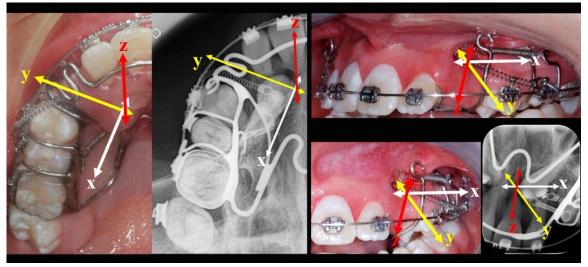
Clinical and radiographic images of palato-buccal movement in the y-axis (yellow arrow), mesio-distal movement in the x-axis (white arrow), and extrusive movement in the z-axis (red arrow) of palatally and buccally MIC with Ni-Ti closed coil springs activated over the rigid anchorage.
